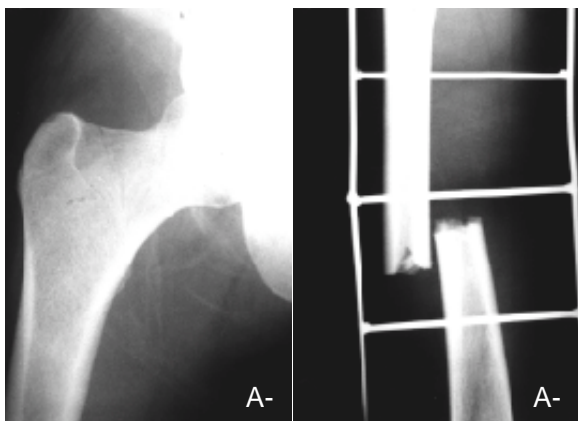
Initial roentgenogram of 28 year old male patient shows femoral midshaft fracture and femoral neck fracture (basicervical and subcapital).
